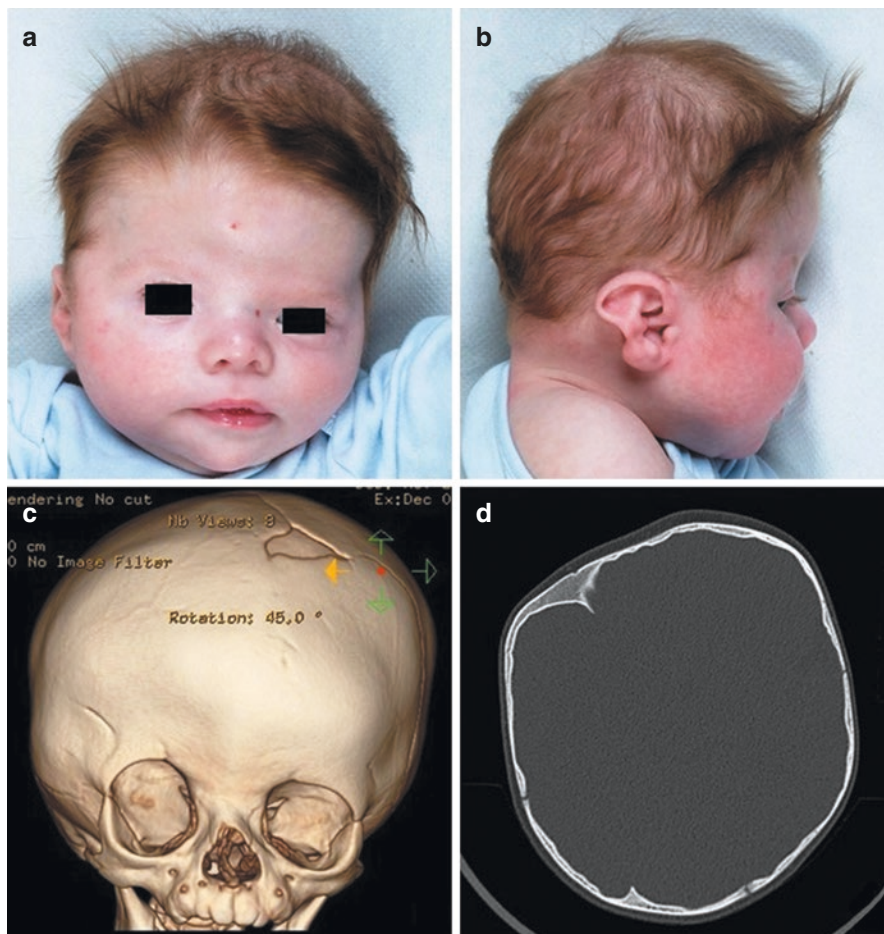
Saethre-Chotzen syndrome. (a) face of affected child; (b) lateral view of the same patient; (c) 3D computed tomography (CT) reconstruction of the patient's skull (anterior view); (d) computed tomography (CT) of the same skull (transverse section at the level of midbrain)
